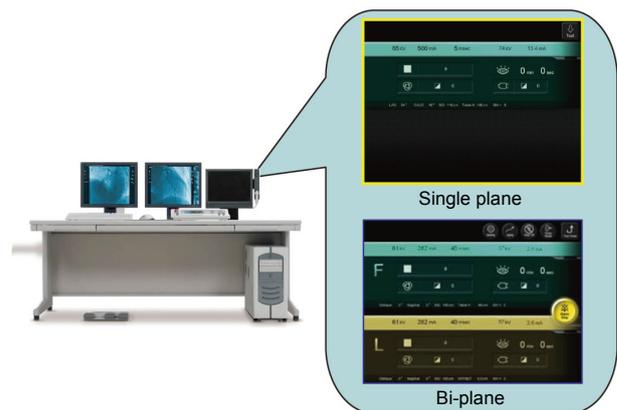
X-Ray Control Console: System Display
